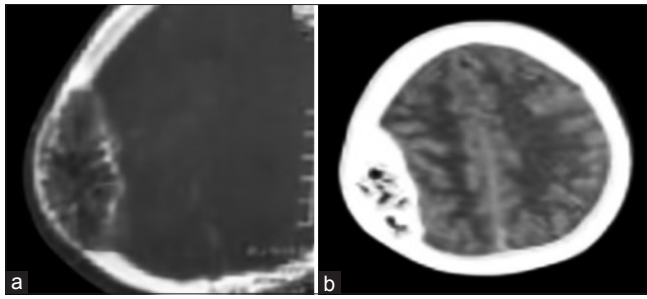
(a and b) Computed tomography of the brain revealed a hyperdense osteolytic lesion within the diploe on the right parietal bone with a characteristic “spoke-wheel” or “honeycomb” pattern
